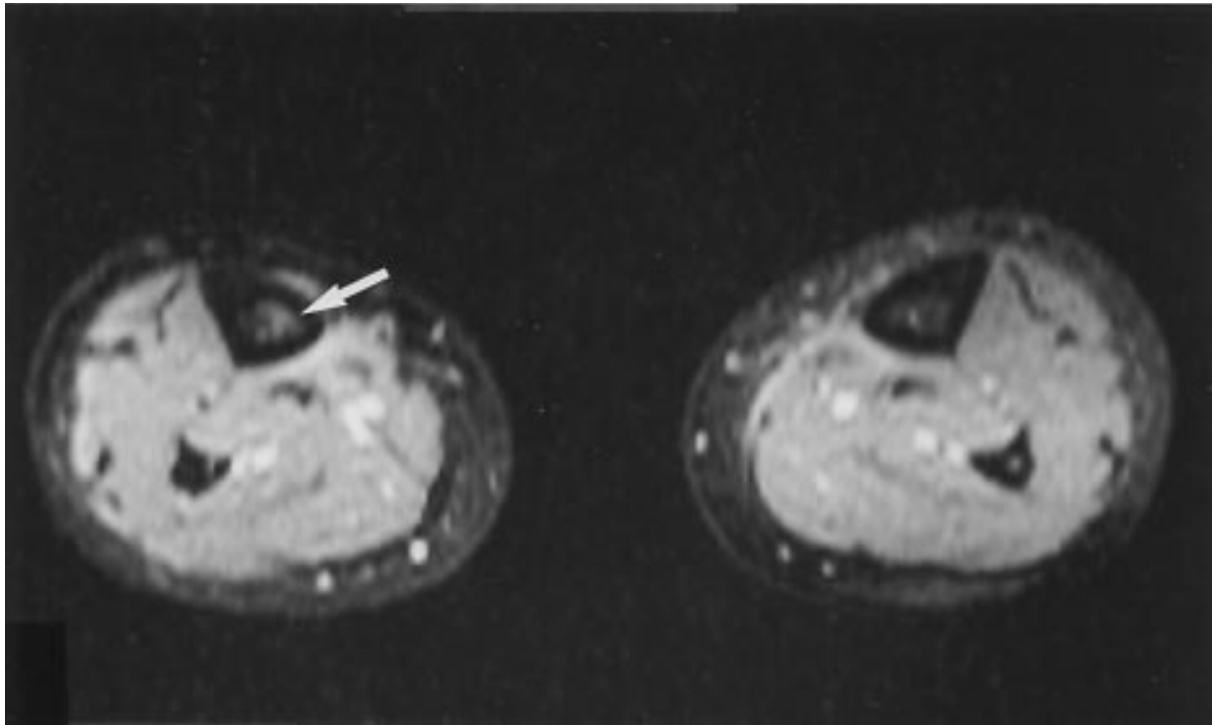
«Axial T2-weighted image of an athlete with medial tibial stress syndrome (MTSS) showing periosteal edema on the anteromedial side of the tibia». From Moen et al. (2014). Reused with permission.
